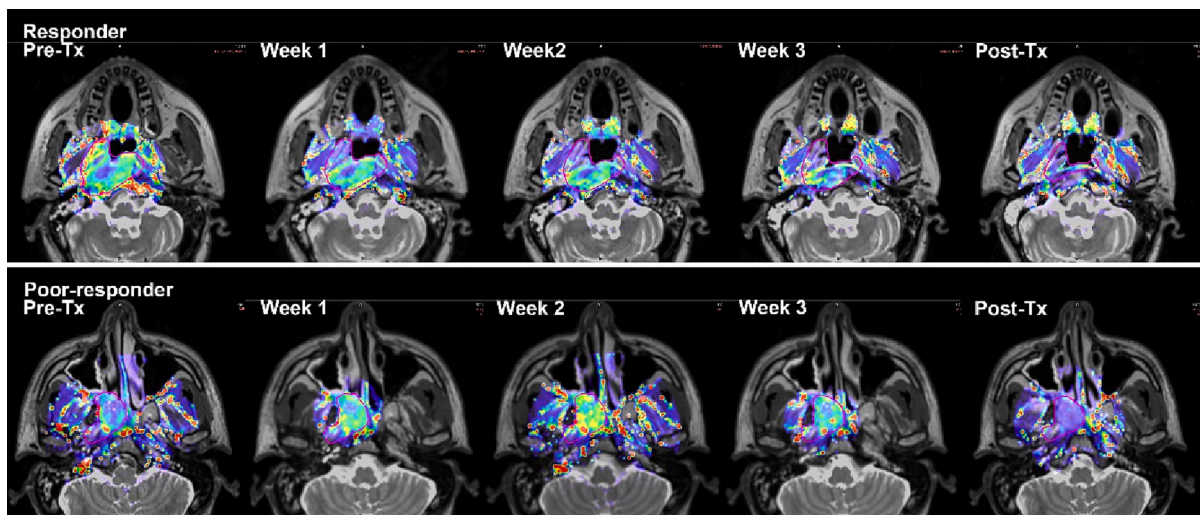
Examples of the iAUC60 changes for a responder (upper row) and a poor-responder (lower row). The gross tumours were delineated in magenta contour. Conspicuous increase in iAUC60 was observed in the poor-responder on week 2 DCE-MRI scan. (For interpretation of the references to colour in this figure legend, the reader is referred to the web version of this article.)
